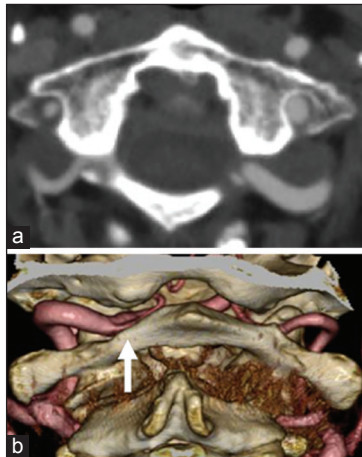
Axial computed tomography angiography (CTA) in Case 2 (a) showing posterolateral protrusion of bilateral vertebral artery (VA). 3D CTA images in Case 2 (b) showing left dominant VA recessed by being caught between the posterior arch of the atlas and occipital bone (white arrow)
